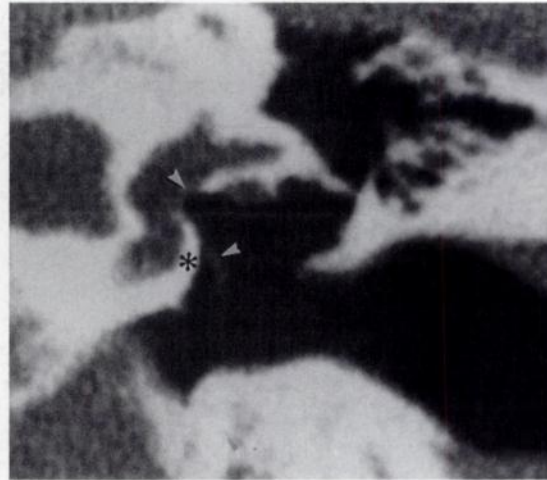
Fracture of the crura of the stapes. Coronal CT scan through the oval window of the left ear shows the footplate in a normal position (top arrowhead). The fractured crura and head of the stapes are displaced downward (bottom arrowhead) near the promontory (*).
